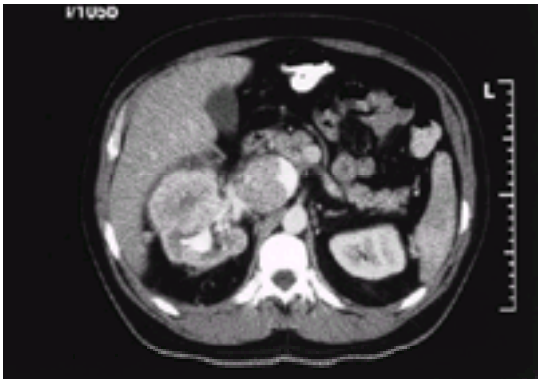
Renal cell carcinoma with extension into the inferior vena cava on CT scan.
